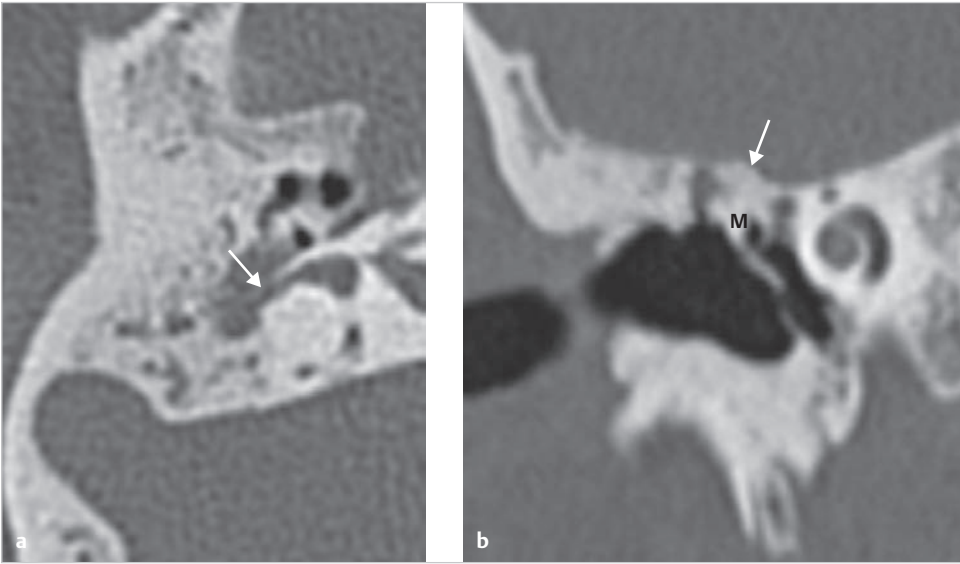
A case of cholesteatoma with labyrinthine fistula. The axial CT shows presence of a large fistula in the lateral semicircular canal (a). In the coronal section, complete fixation of the head of the malleus by tympanosclerosis is demonstrated. In spite of such severe change, the tympanic cavity is well aerated (b), and hearing stays usable due to myringostapediopexy. M, malleus.
